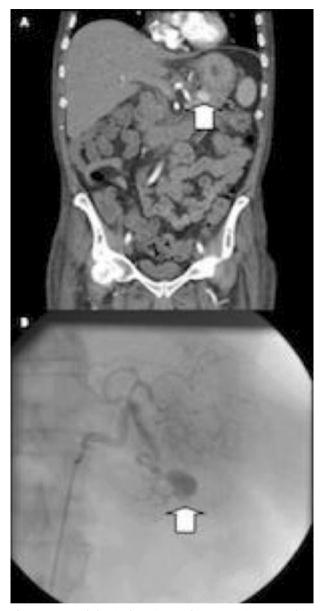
A. Abdominal CT image from Case 2. A pseudoaneurysm of the left gastric artery (arrow) is shown. B. Arteriography of the superior mesenteric artery showing the pseudoaneurysm (arrow).
